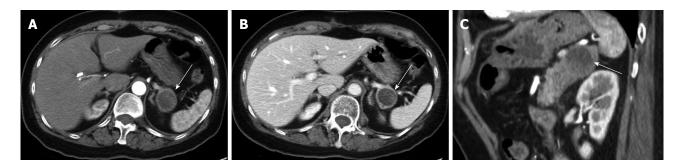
Follow-up computed tomography imaging 13 mo later. The arterial phase (A), portal venous phase (B) and oblique sagittal contrast-enhanced computed tomography image (C) showed the lesion grew up to 2.9 cm in diameter with heterogeneous enhancement in the more thickened wall and solid component.
